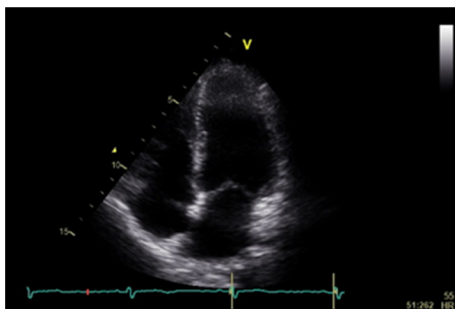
Apical 4-chamber view of a cardiac ultrasound image.
